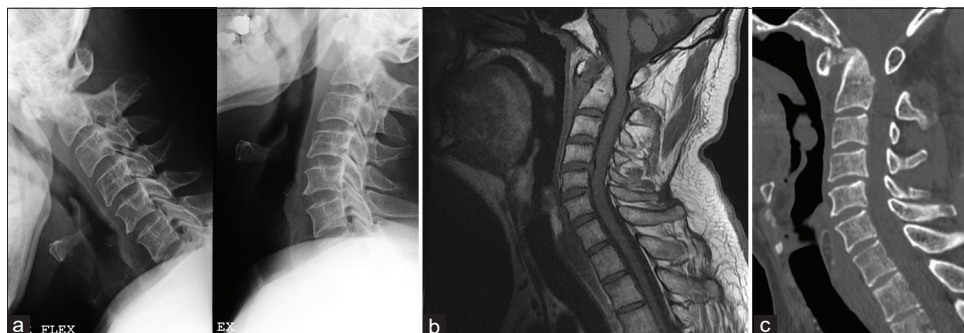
(a) The atlantoaxial complex is stable on lateral dynamic X-rays with atlantodental interval (ADI) in range (<3 mm). (b) Sagittal T1 magnetic resonance imaging – no retropharyngeal mass persists, but the C2 dens is significantly dorsally displaced causing central cervical canal stenosis. ADI is pathologically increased (14 mm) with evidence of subluxation and C1-C2 stenosis. (c) Sagittal computed tomography (bone) – evidence of alar and transverse ligament involvement with calcification of the osteoligamentous complex.
